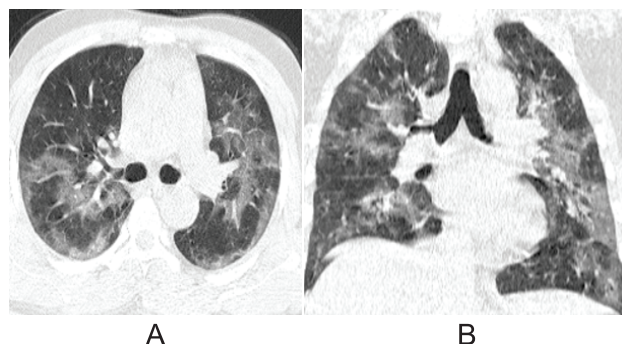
HRCT chest axial (A) and coronal (B) images show bilateral, multifocal, ground-glass opacities with septal thickening (giving a crazy-paving pattern). Findings consistent with COVID-19 pneumonia were reported however, RT-PCR came out to be negative.
